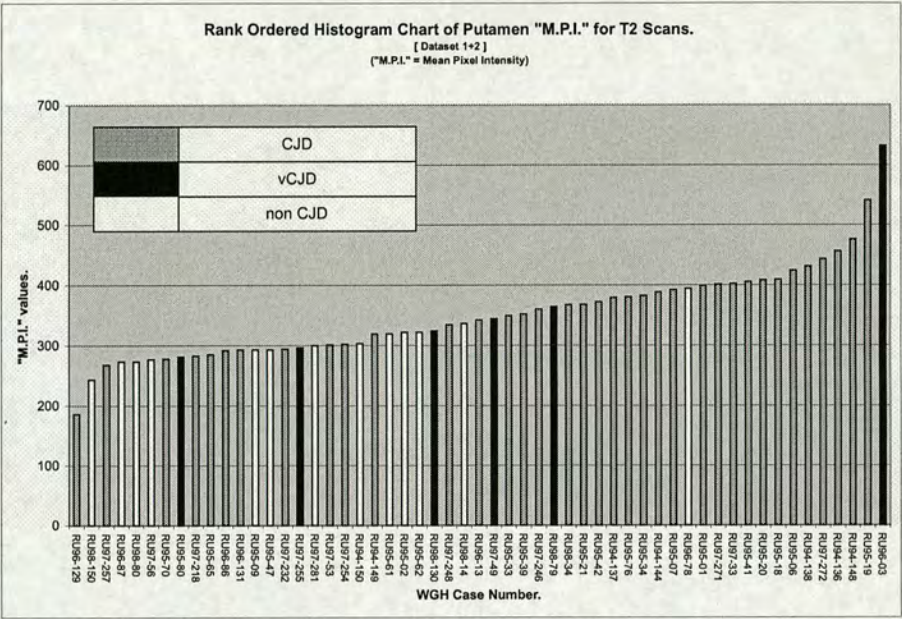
Putamen Tests: Rank ordered histogram of the Putamen region "M.P.I." values for the T2 weighted MRI scan-data from datasets 1 & 2 combined.
